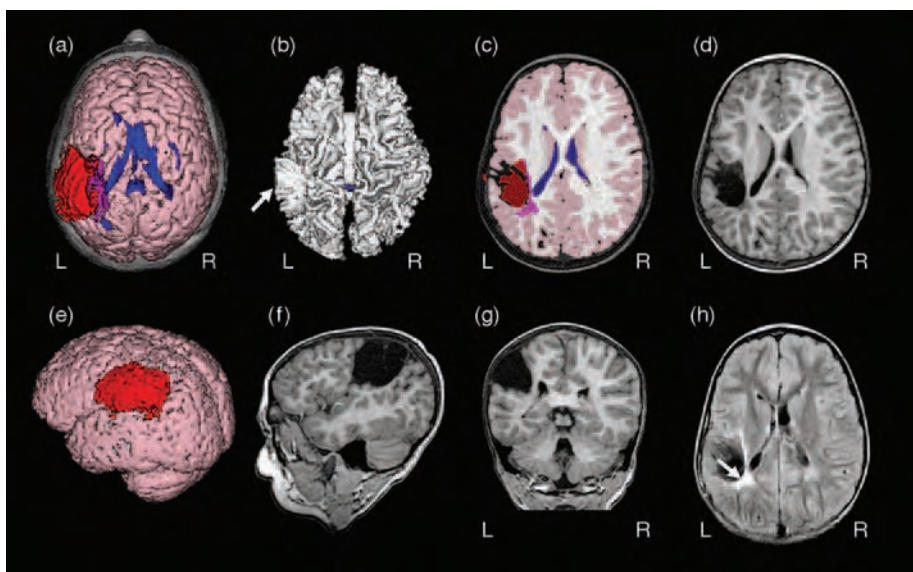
This child sustained a focal birth-related injury to the left superior and posterior temporal lobe and parietal cortex, traditional areas critical for language function. The extent of damage is clearly defined by the large cystic lesion that is visible. Despite the extensive damage, when the abnormality is focal like this and in the immature brain, often considerable adaptation and recovery can occur. Unlike the case in Figure 19.8, with a somewhat similar location of extensive left hemisphere damage but occurring in adolescence rather than infancy, this child in Figure 19.6 was showing relatively intact language development. Also, as compared to the child with birth-related injury, but with bilateral damage, the child shown in Figure 19.7 did not show adaptation. (a) 3-D dorsal view, (b) Cerebral white matter has been isolated, with the arrow pointing to the large region of disrupted white matter, (c) color segmented image showing color-coded white and gray matter, CSF and lesion as depicted in the T1 image shown in (d), (e) posterior oblique 3-D view showing the location of the focal lesion, (f) T1 sagittal view depicting the location of the cystic lesion, (g) T1 coronal image showing location of the cystic lesion, and (h) FLAIR sequence showing the sensitivity of this scan in detecting white matter pathology not as readily observed on the T1 scan (compare to d).
